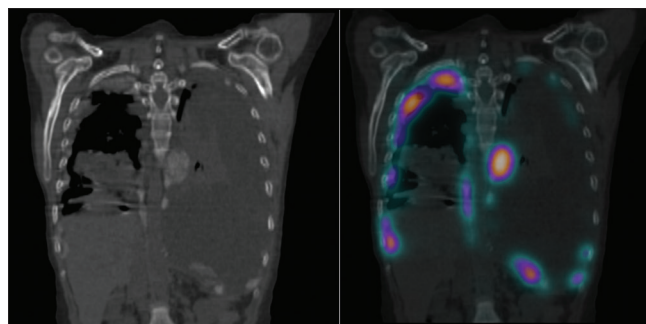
Coronal computed tomography image showing multiple calcified foci of thickening and nodules in both pleura (left) and the single-photon emission computed tomography/computed tomography fusion showing the ^{99m}technetium methylene diphosphonate uptake correspondence in these areas (right)
